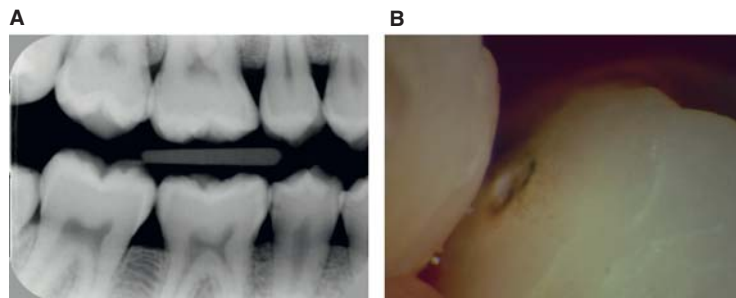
(A) Bitewing radiograph of patient showing a caries lesion into outer third of dentine in the distal surface of 45, (B) cavity in the same surface observed after tooth separation.
